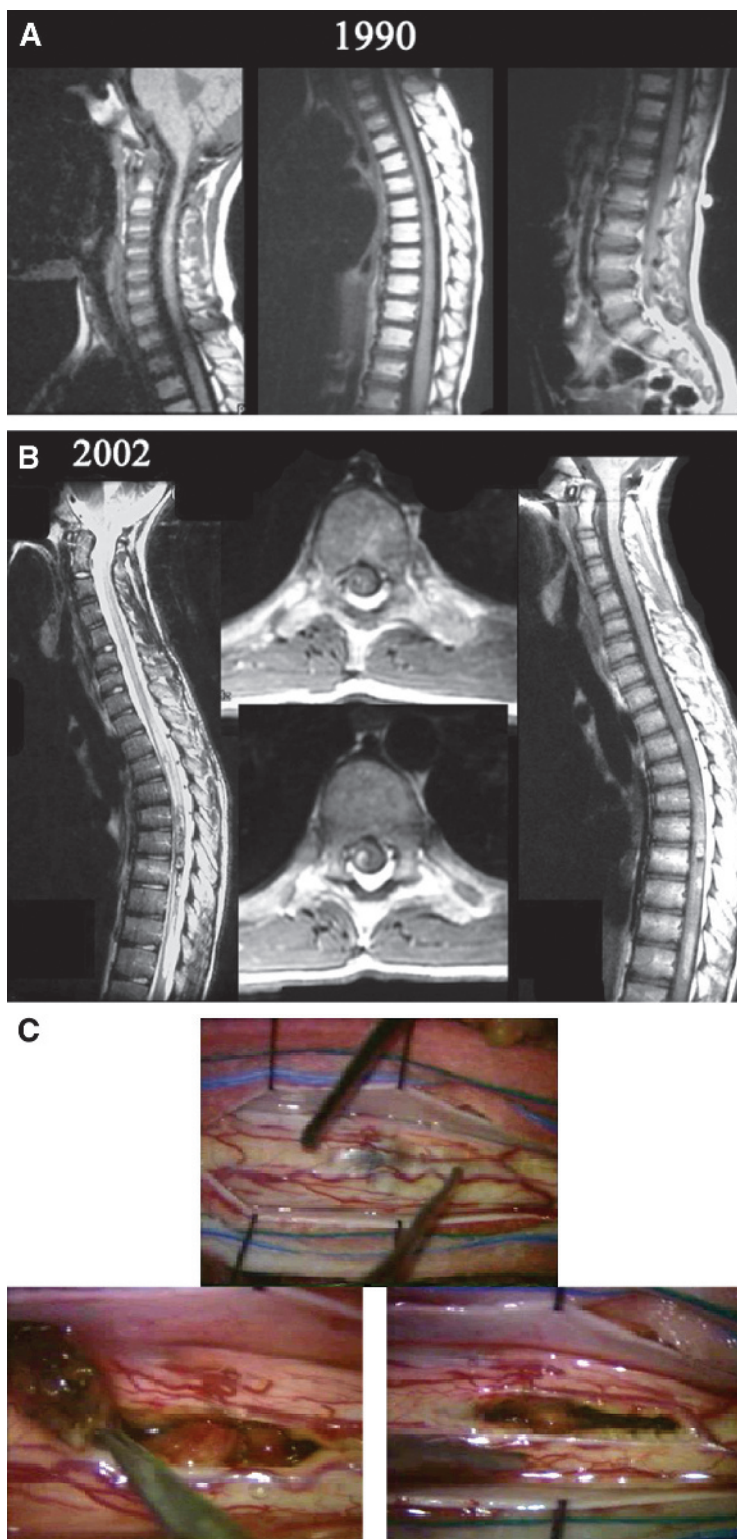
A, normal spinal MRI from 1990 in a 1-year-old child before undergoing total craniospinal radiation therapy after resection of a medulloblastoma. B, spinal MRI from 2002 showing cavernous malformations after the patient presented with a thoracic myelopathy. C, intraoperative photographs showing removal of pathologically proven radiation-induced cavernous malformation.
